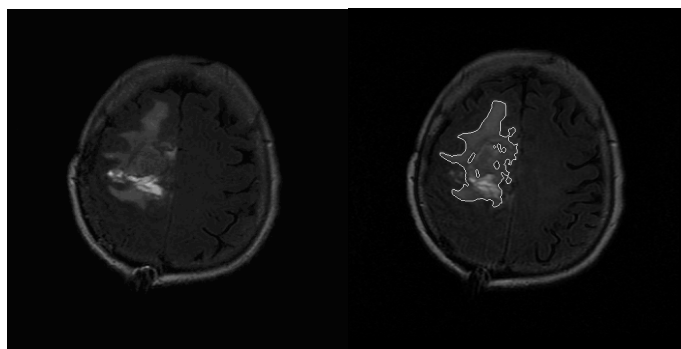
Examples of traditional SVM (FLAIR images)
